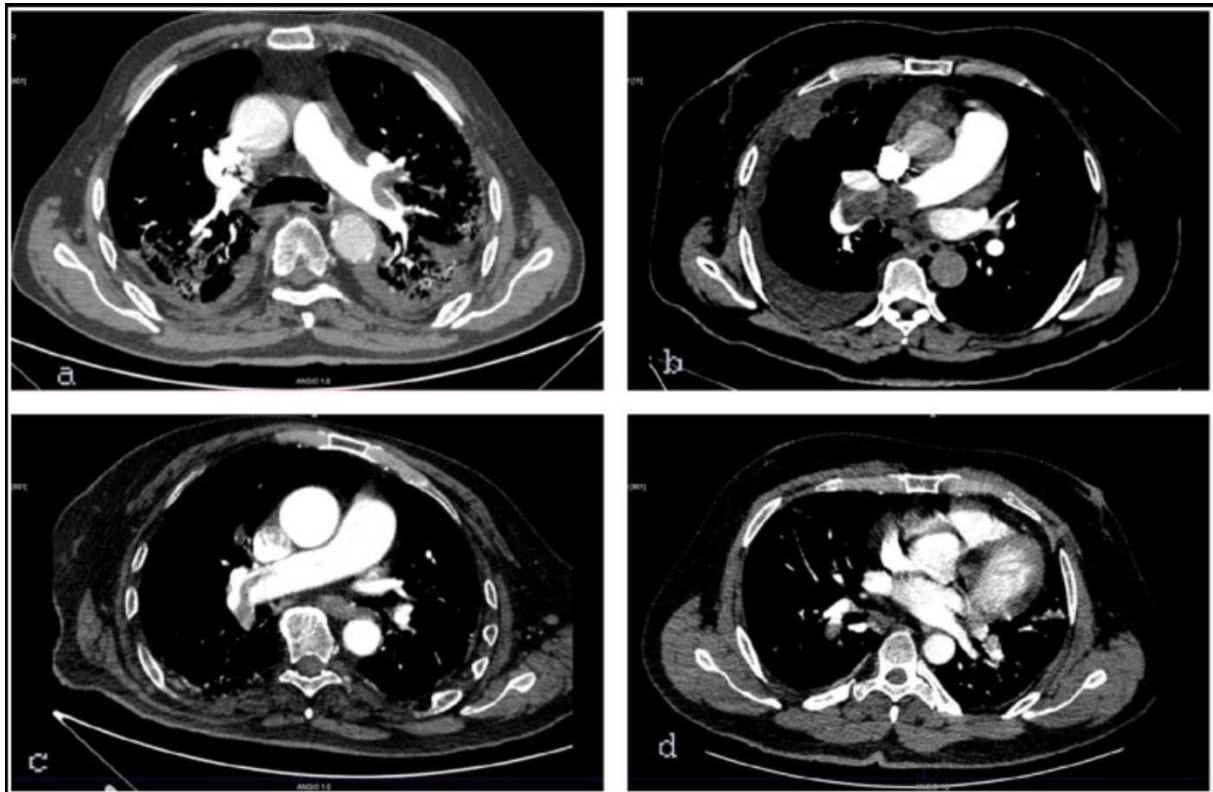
CT angiography scans with pulmonary emboli in Covid-19 patients in acute state (a and b) and after recovering (c and d).
